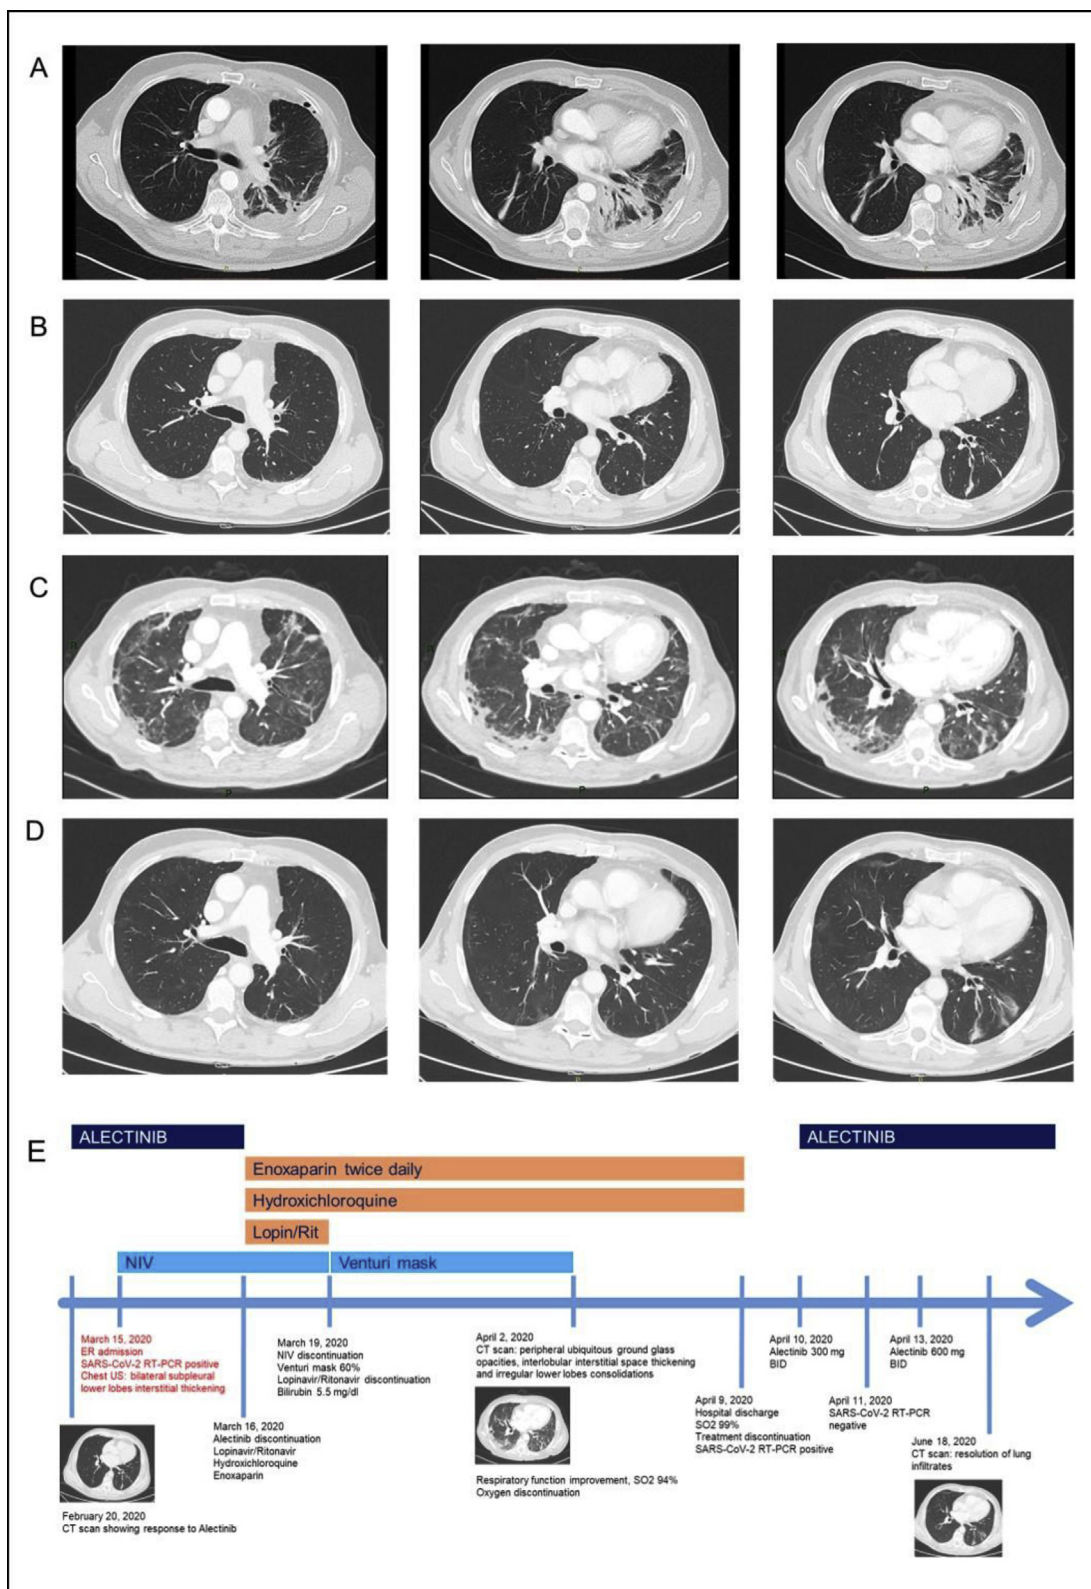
A) CT scan findings at diagnosis of NSCLC. (B) CT scan findings before SARS-CoV-2 infection obtained 20 days before hospital admission, showing persistent response to alectinib. (C) CT scan findings during hospitalisation. (D) CT scan finding obtained two months after hospital discharge showing an almost complete resolution of lung infiltrates due to COVID-19; no clear radiological signs of cancer disease progression are evident. (E) Timeline summary displaying the clinical and radiological evolution of the disease. Lopin/Rit = lopinavir/ritonavir; CT = computed tomography; COVID-19 = coronavirus disease 2019; NSCLC = non-small-cell lung cancer; SARS-CoV-2 = severe acute respiratory syndrome coronavirus 2.
